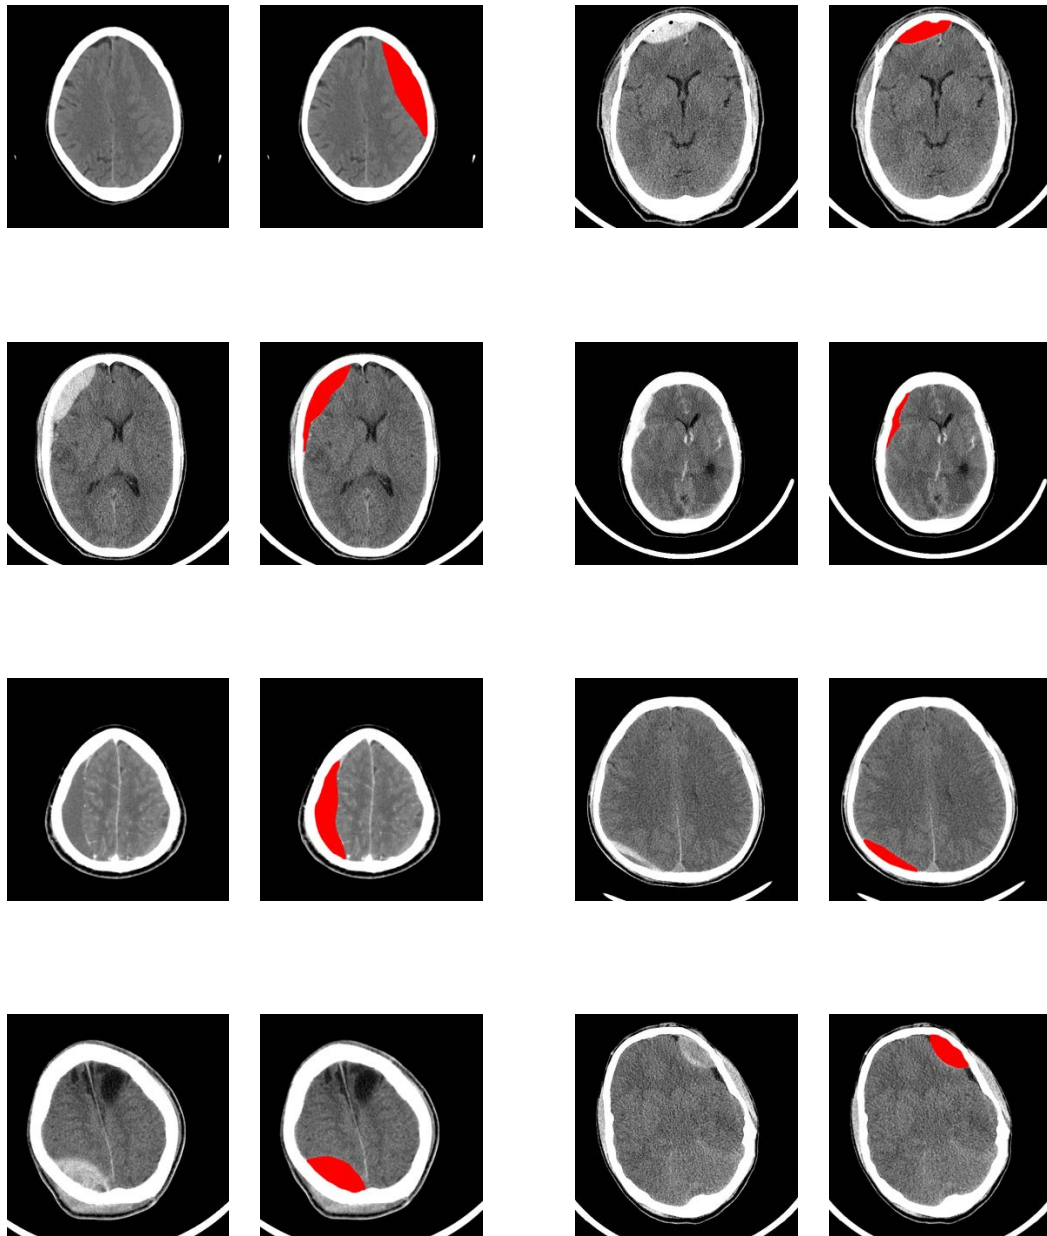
Manual annotation of ROI by radiology experts. Images in first and third columns are the brain CT scans from TBI patients. Images in the second and fourth columns show the respective haematomas highlighted by the experts.
